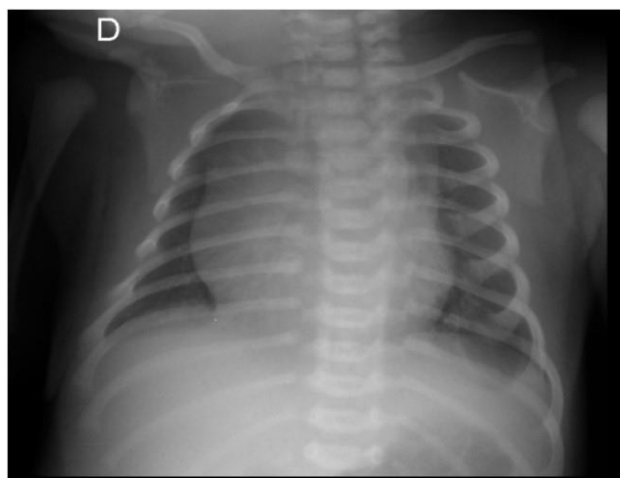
Chest x-ray showing an increased cardiothoracic ratio and a bilateral pneumomediastinum.
